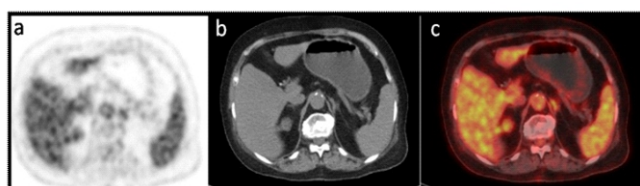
A 83 years old woman with ESRD on hemodialysis who underwent ^{18}F -FDG PET/CT imaging. Positron emission tomography image and fusion PET/CT image (a, c) show increased FDG uptake in walls of the abdominal aorta due to atherosclerotic inflammation. Standardized uptake maximum value and SUVmean were 2.6 and 2.5, respectively. Two small foci of high attenuation macroscopic atherosclerotic calcification were detected on the low-dose CT image (b) at the same level.
